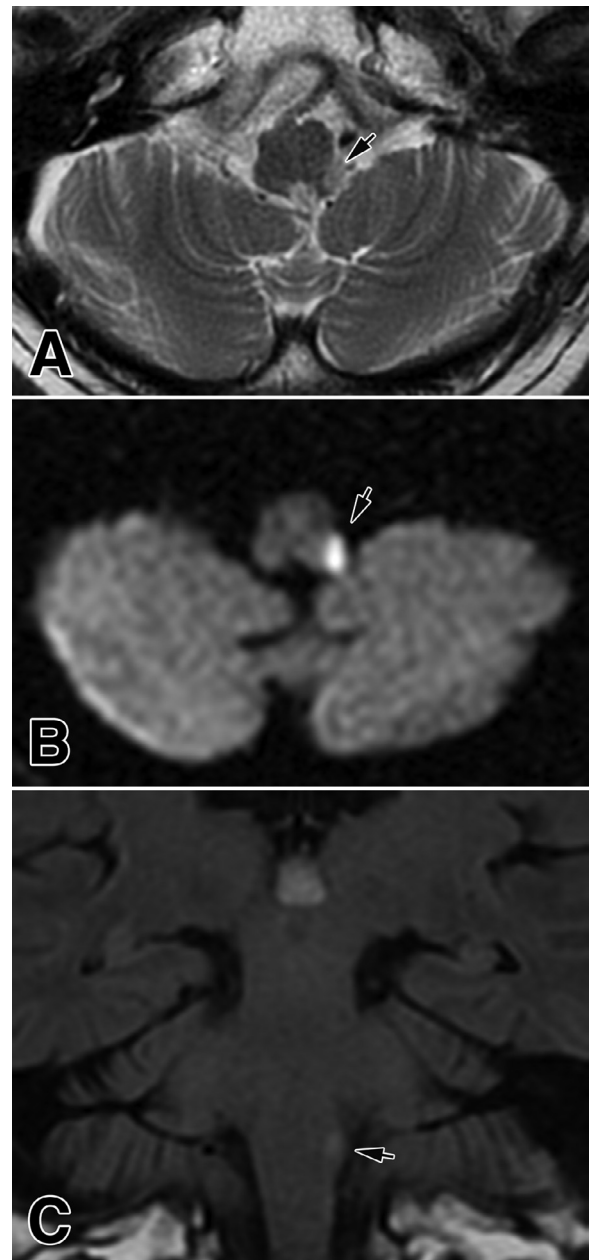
A left laterodorsal infarction (arrows) of the middle medulla in the axial T2-weighted (A), and DWI (B) images, and in the coronal FLAIR section (C).
